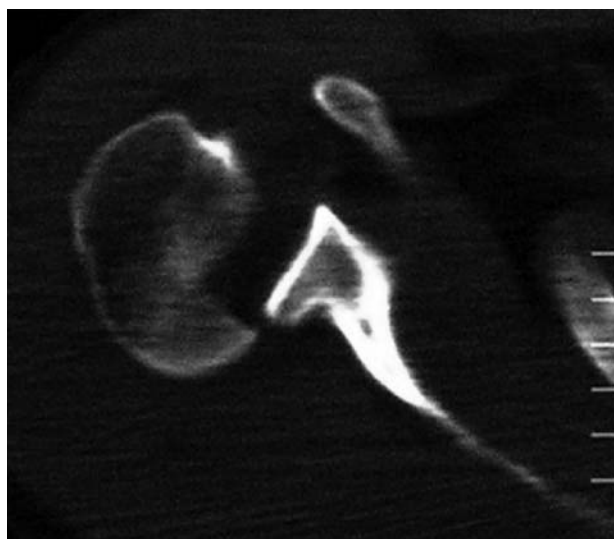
Preoperative axial CT image of the right shoulder.
